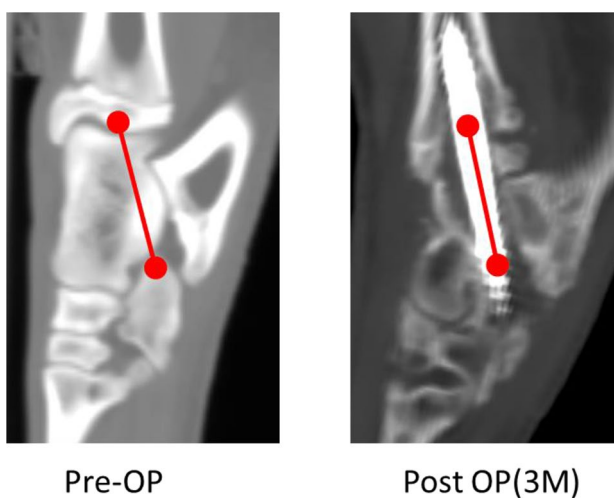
Comparative analysis of the TTC nail compression effectiveness. CT measurements at sagittal plane showing bone distance between calcaneus and tibia before and 3 months after surgery. Compression capability ratio (postoperative/preoperative distance percentage) demonstrated superior performance of both TTC 1 and TTC 4 (82.5% and 81.0% compression rate respectively)
